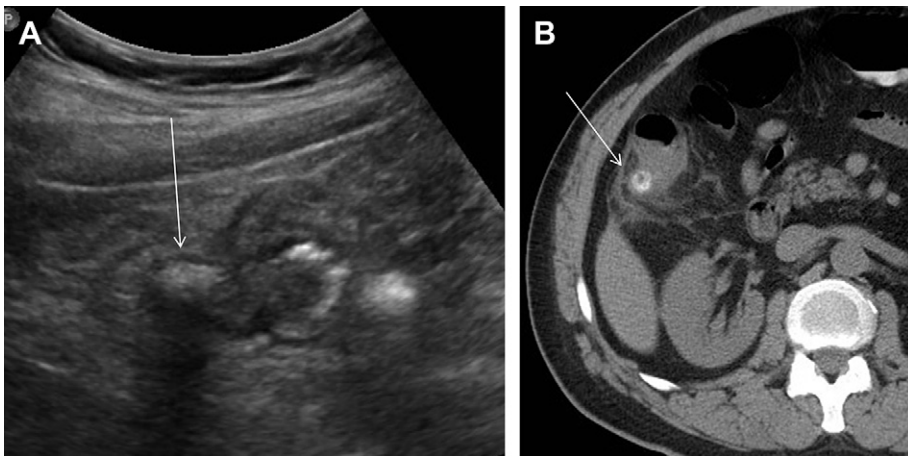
(A) Young male patient presenting to US to rule out appendicitis. Note focal wall thickening at the neck of a diverticulum (*arrow*) and surrounding echogenic fat. Appendix was seen separately and was normal. (B) Confirmation on CT (*arrow*).
